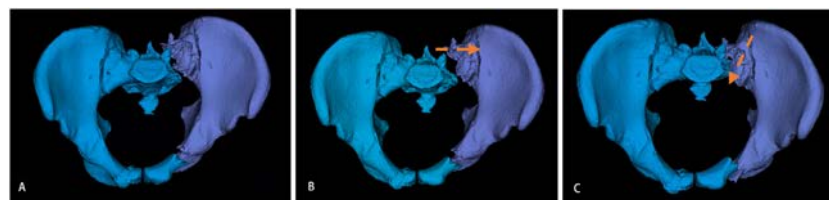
A. Preoperative CT reconstruction model; B. Preoperative path planning of reduction planning; C. Final target position of path planning
